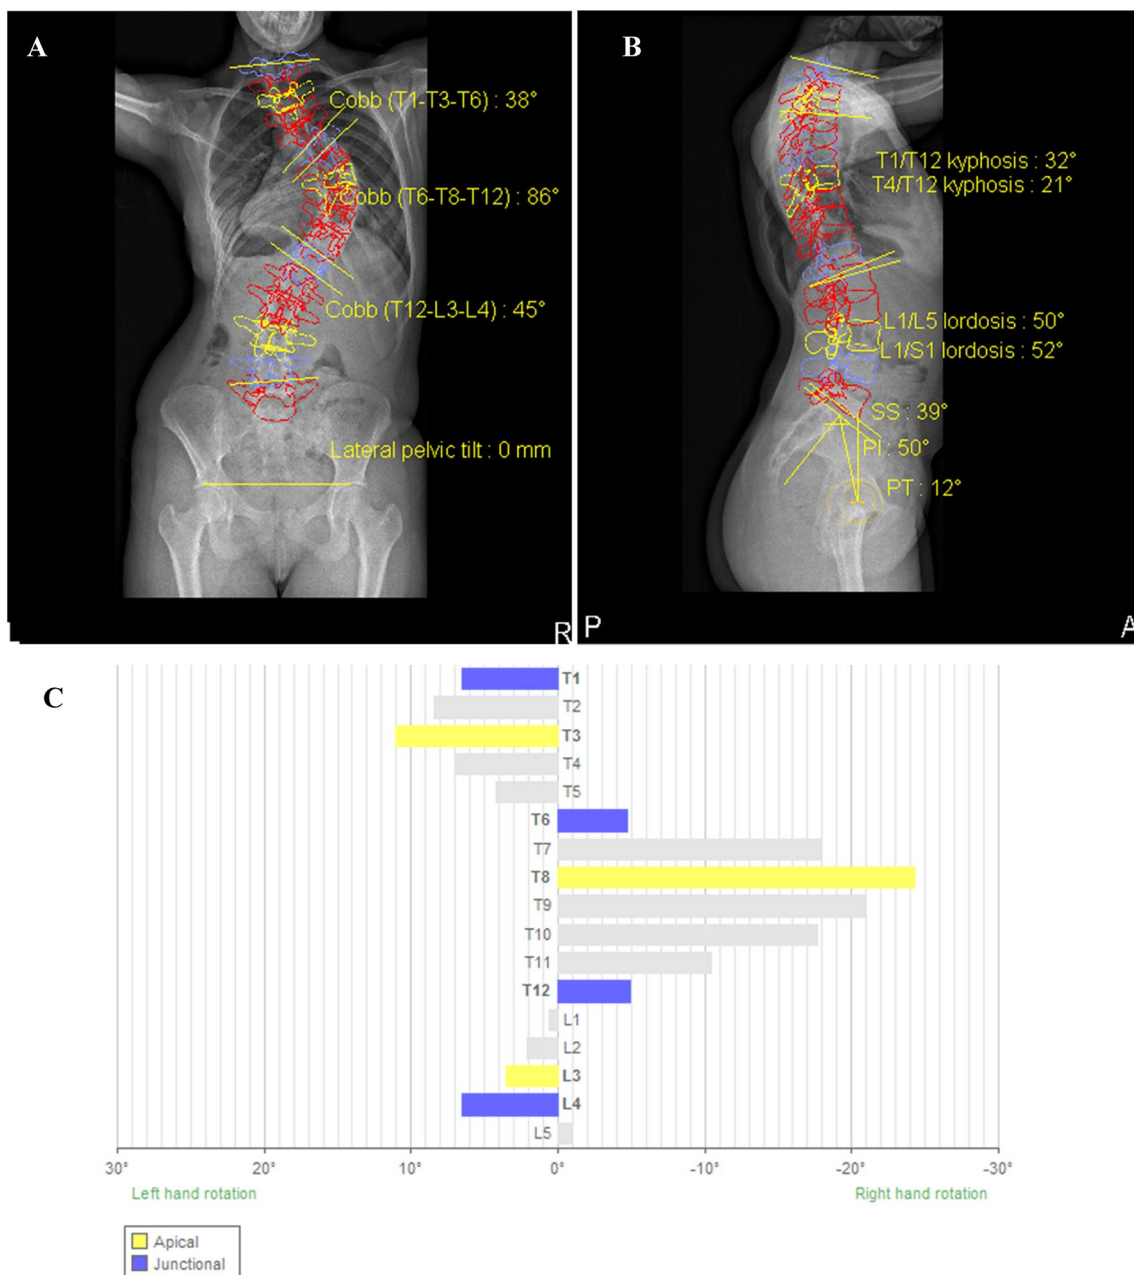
sterEOS three-dimensional (3D) images of a representative clinical case of adolescent idiopathic scoliosis. EOS 3D reconstruction anteroposterior (AP) and lateral (LAT) X-ray images (A, B). C shows each vertebral rotation based on 3D reconstruction (Case 1)
